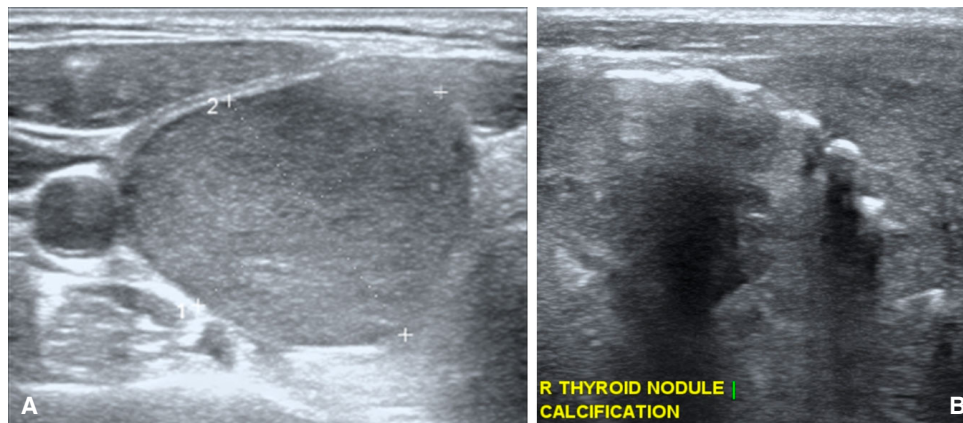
Ultrasound image showing examples of TIRADS 4A. (A) Solid nodule smooth margin, (B) mixed nodule with calcifications.
